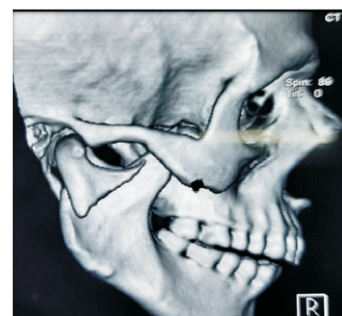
Three Dimensional Computed tomographic image demonstrating fracture of subcondylar region with posterior gagging of occlusion and reduction in ramus height.
